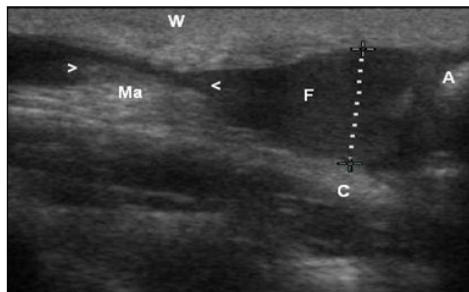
Transabdominal sonogram showed the adhesion grade 4, Massive agglutinating adhesion between colon and abdominal wall (Group 1: Control).
